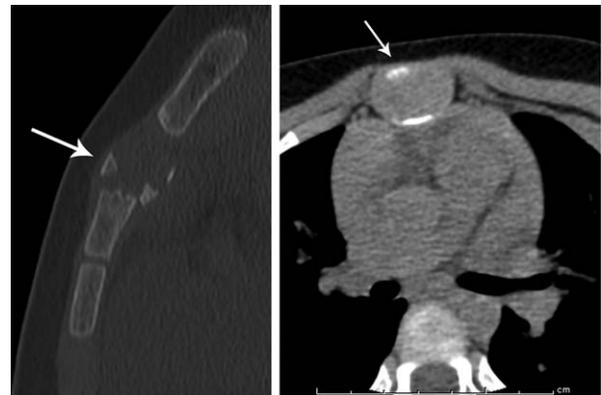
Follow-up CT scan 10 months after initial presentation: (A) Sagittal CT reconstruction of the sternum in bone window shows fragmentation and bone resorption of the first sternal segment (arrow) suggesting osteonecrosis. There is also remodeling of the proximal portion of the second sternal segment. (B) Axial CT scan of the first sternal segment in soft tissue window shows persistent horizontal alignment (arrow) without soft tissue swelling.
